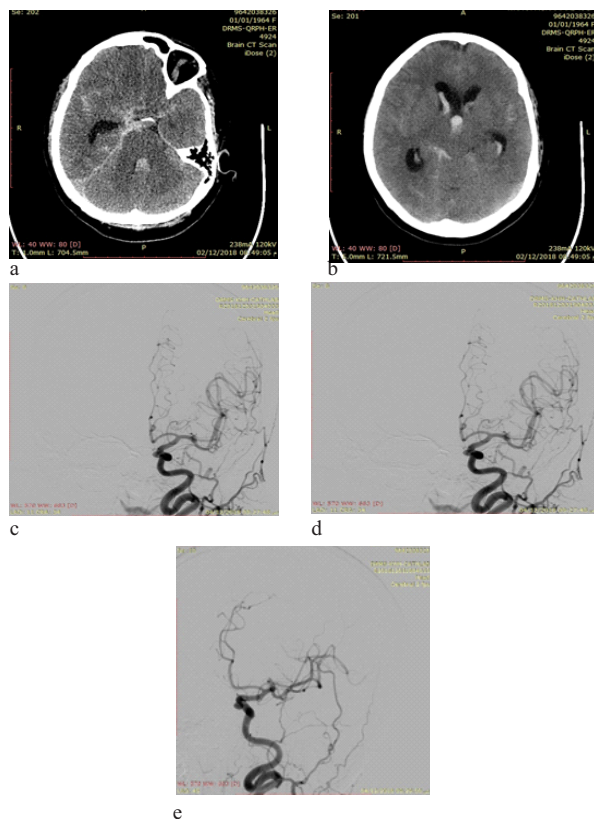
A 55 year old female patient presented with severe headache. Non attenuation CT scan (a) and (b) shows subarachnoid and intraventricular bleeding, DSA (c) townes, (d) lateral and (e) oblique project views show left para-ophthalmic left ICA aneurysm.
